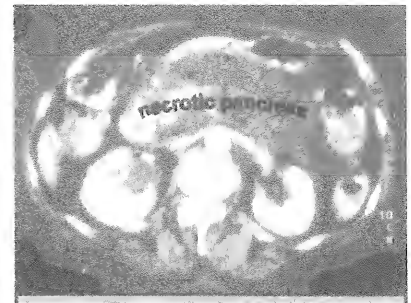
CT scan showing necrotizing pancreatitis
